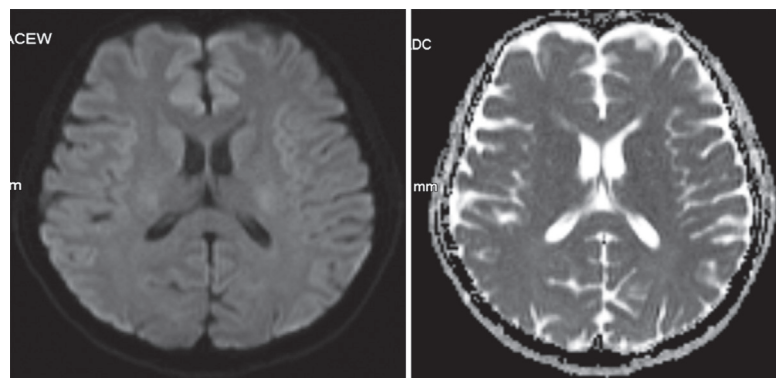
Control diffusion MRI and ADC imaging were normal after 3 months.
